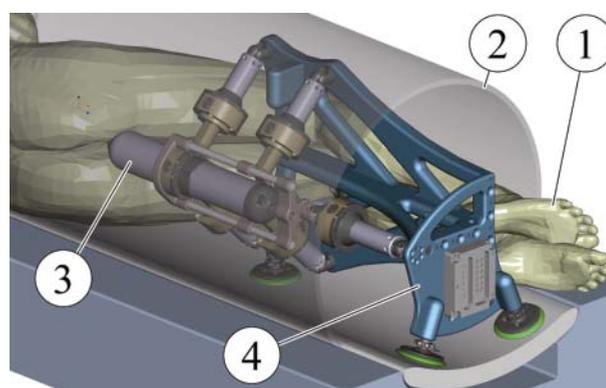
Closed-bore MRI intervention setup
